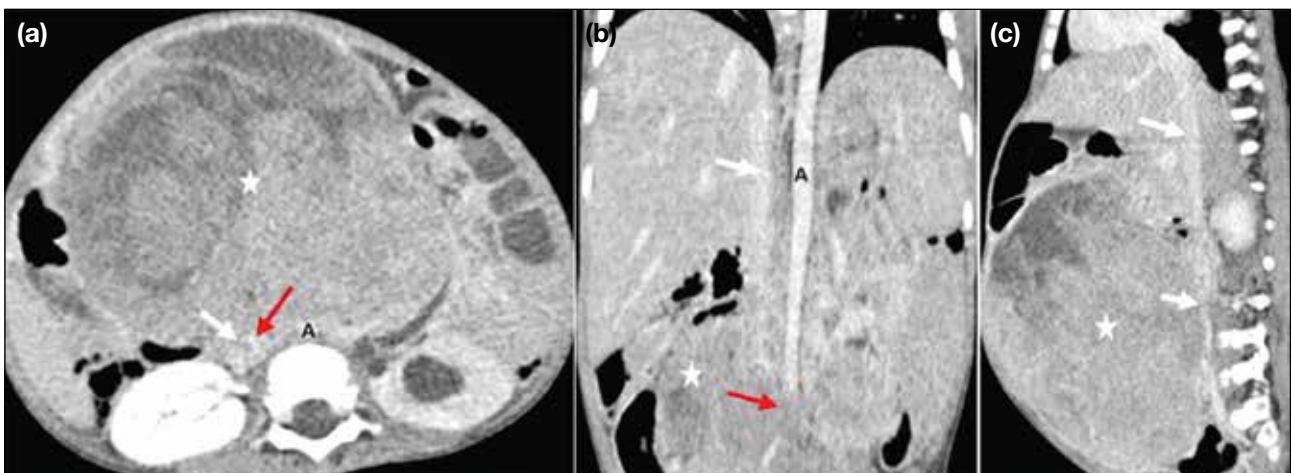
Retroperitoneal rhabdomyosarcoma in a 4-year-old child. (a) Axial, (b) coronal, and (c) sagittal contrast-enhanced computed tomography images show a large heterogeneously enhancing soft tissue-attenuation mass (stars) partially encasing, compressing, and narrowing the inferior vena cava (white arrows), with infiltration of the vessel wall (red arrows in [a] and [b]). Abbreviation: A = aorta.
